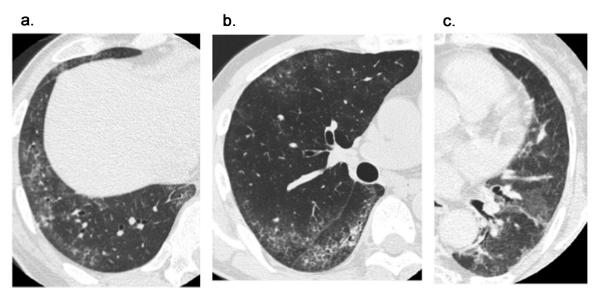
Ground-glass attenuation. (a) Thin-section CT scan of the right lung in a 44-year-old man with ARS-ILD (EJ) shows areas with ground-glass attenuation in peripheri. (b) Thin-section CT scan of the right lung in a 50-year-old man with ARS-ILD (KS) demonstrates areas with ground-glass attenuation in both peripheral and peribronchovascular regions. (c) Thin-section CT scan of the left lung in a 50-year-old man with ARS-ILD (KS) depicts areas with ground-glass attenuation in peribronchovascular regions.
